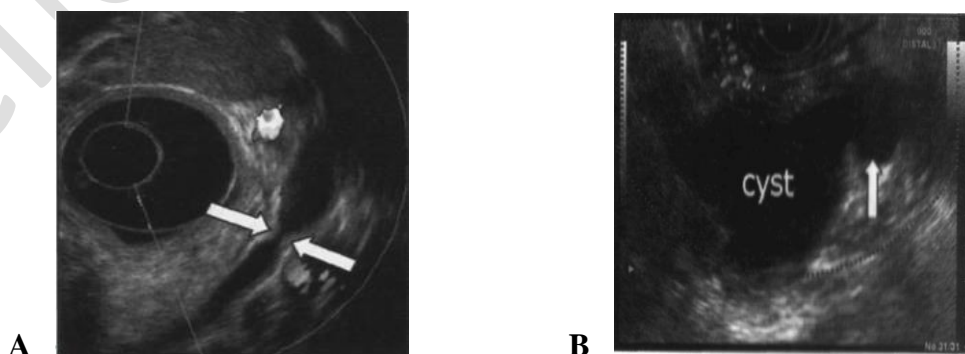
Typical ultrasound of pancreas:
